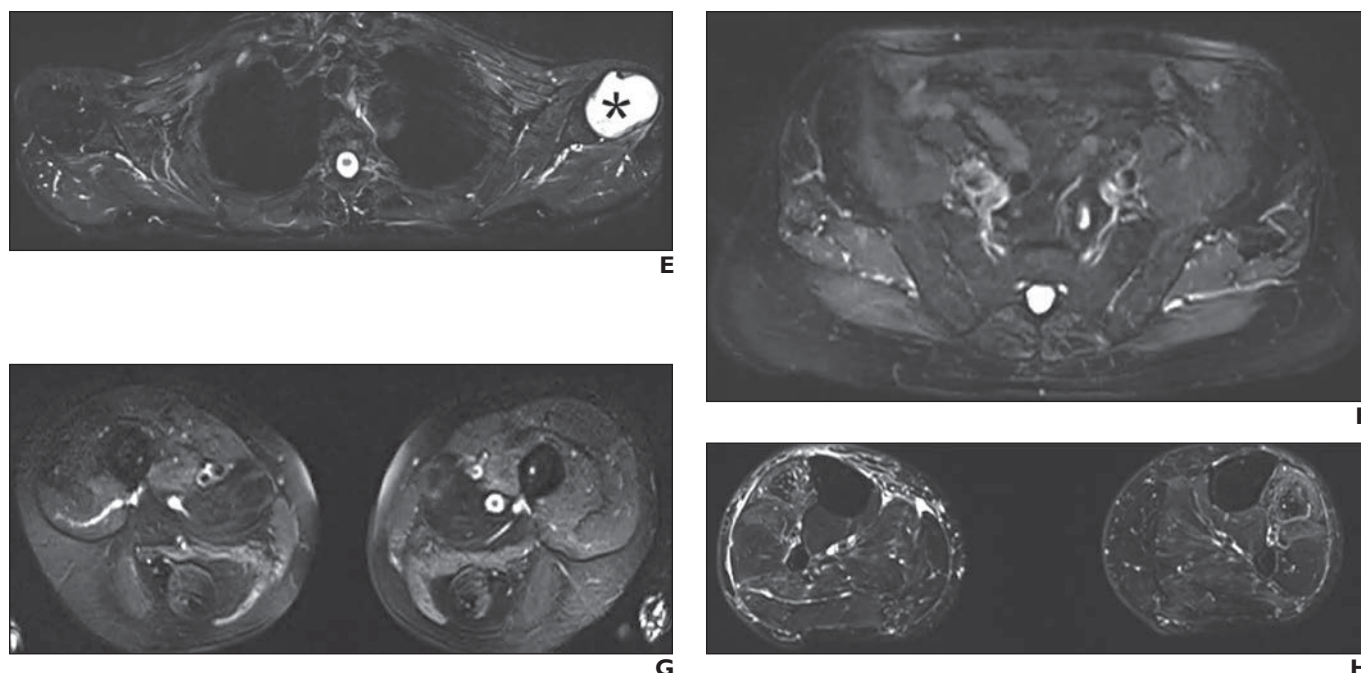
(continued)—70-year-old patient with limb girdle muscular dystrophy who underwent whole-body MRI examination that included axial fast spin-echo T2-weighted Dixon sequences.
